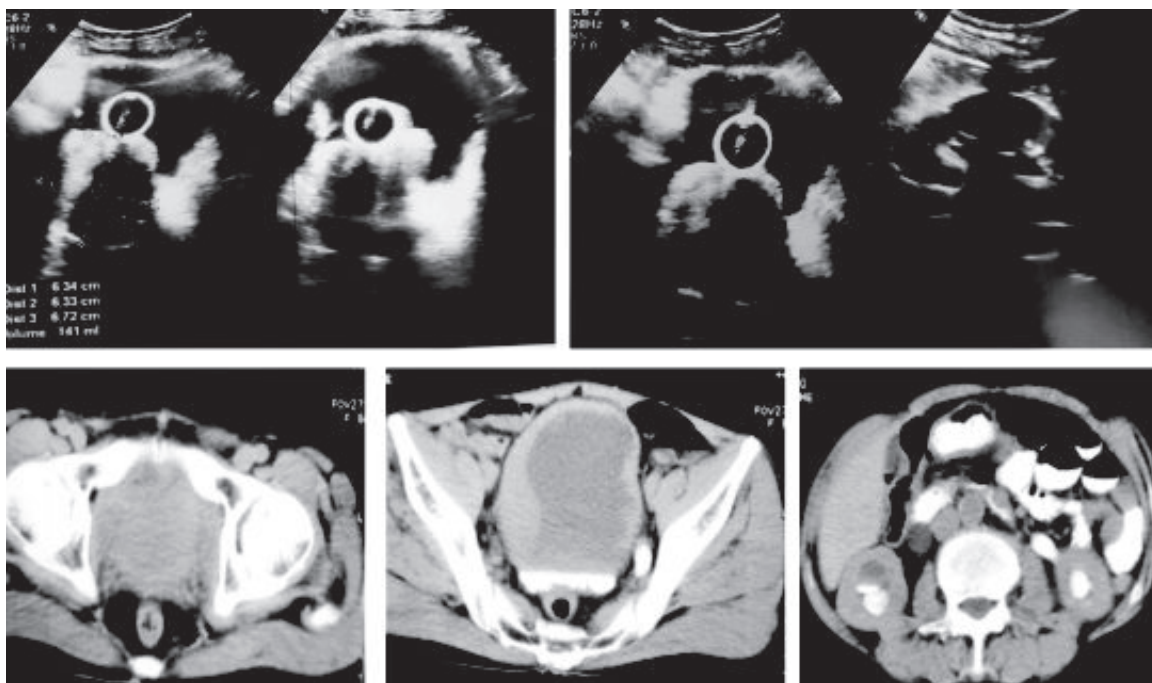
& 3b (Top images): *USG images showing obvious massive enlargement of median lobe of prostate protruding in bladder base resulting in bilateral hydronephrosis. Fig 3a, 3b & 3c: CT axial images of the same patient showing bilateral obstructive uropathy.*
